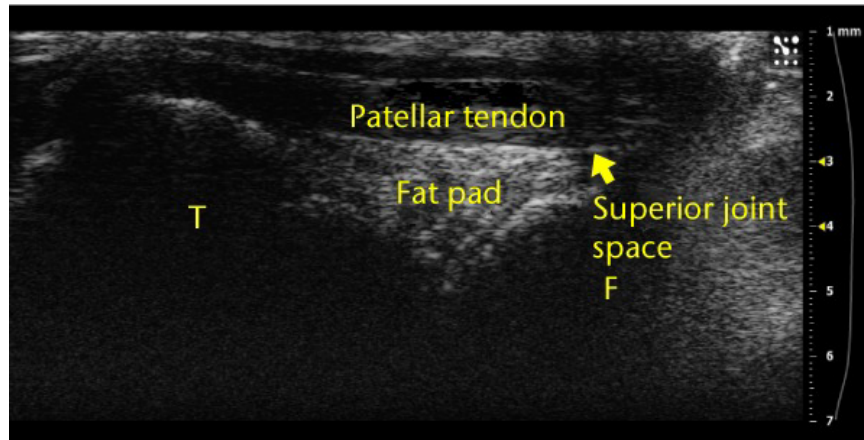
Example ultrasound image of a knee joint with labels over the femur ('F'), tibia ('T'), superior joint space and fat pad. These anatomical landmarks were observed for each injection.
